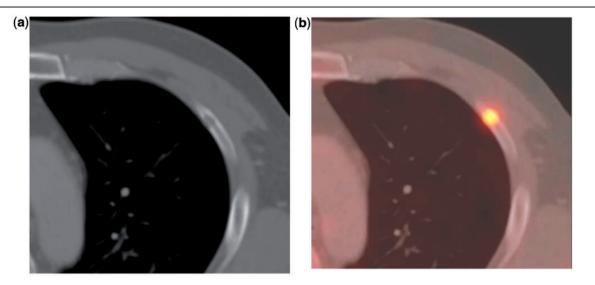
A 63-year-old man with melanoma. (a) A tiny lytic lesion to the rib cage, consistent with melanoma metastasis, is seen on CT. (b) On PET/CT the lesion is clearly demonstrated.
